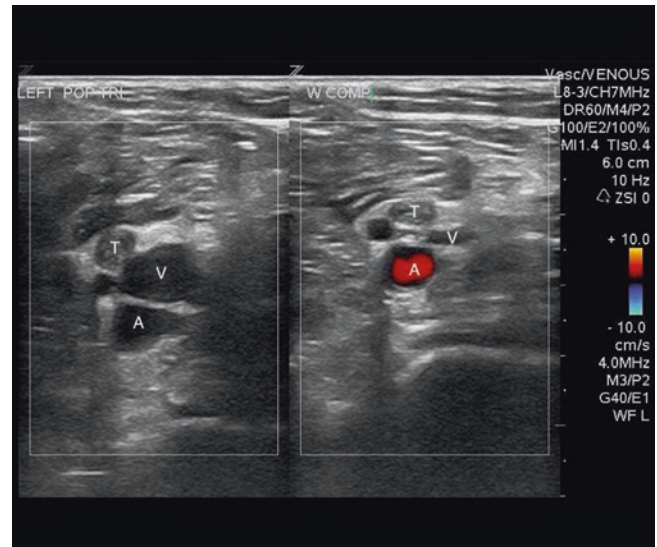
This a split screen image of the popliteal fossa normally on the left, and with compression on the right with color doppler. A small thrombus (T) is evident one of the branches within the trifurcation of the popliteal vein (V). The artery (A) does not collapse. Courtesy of Christopher Gelabert
